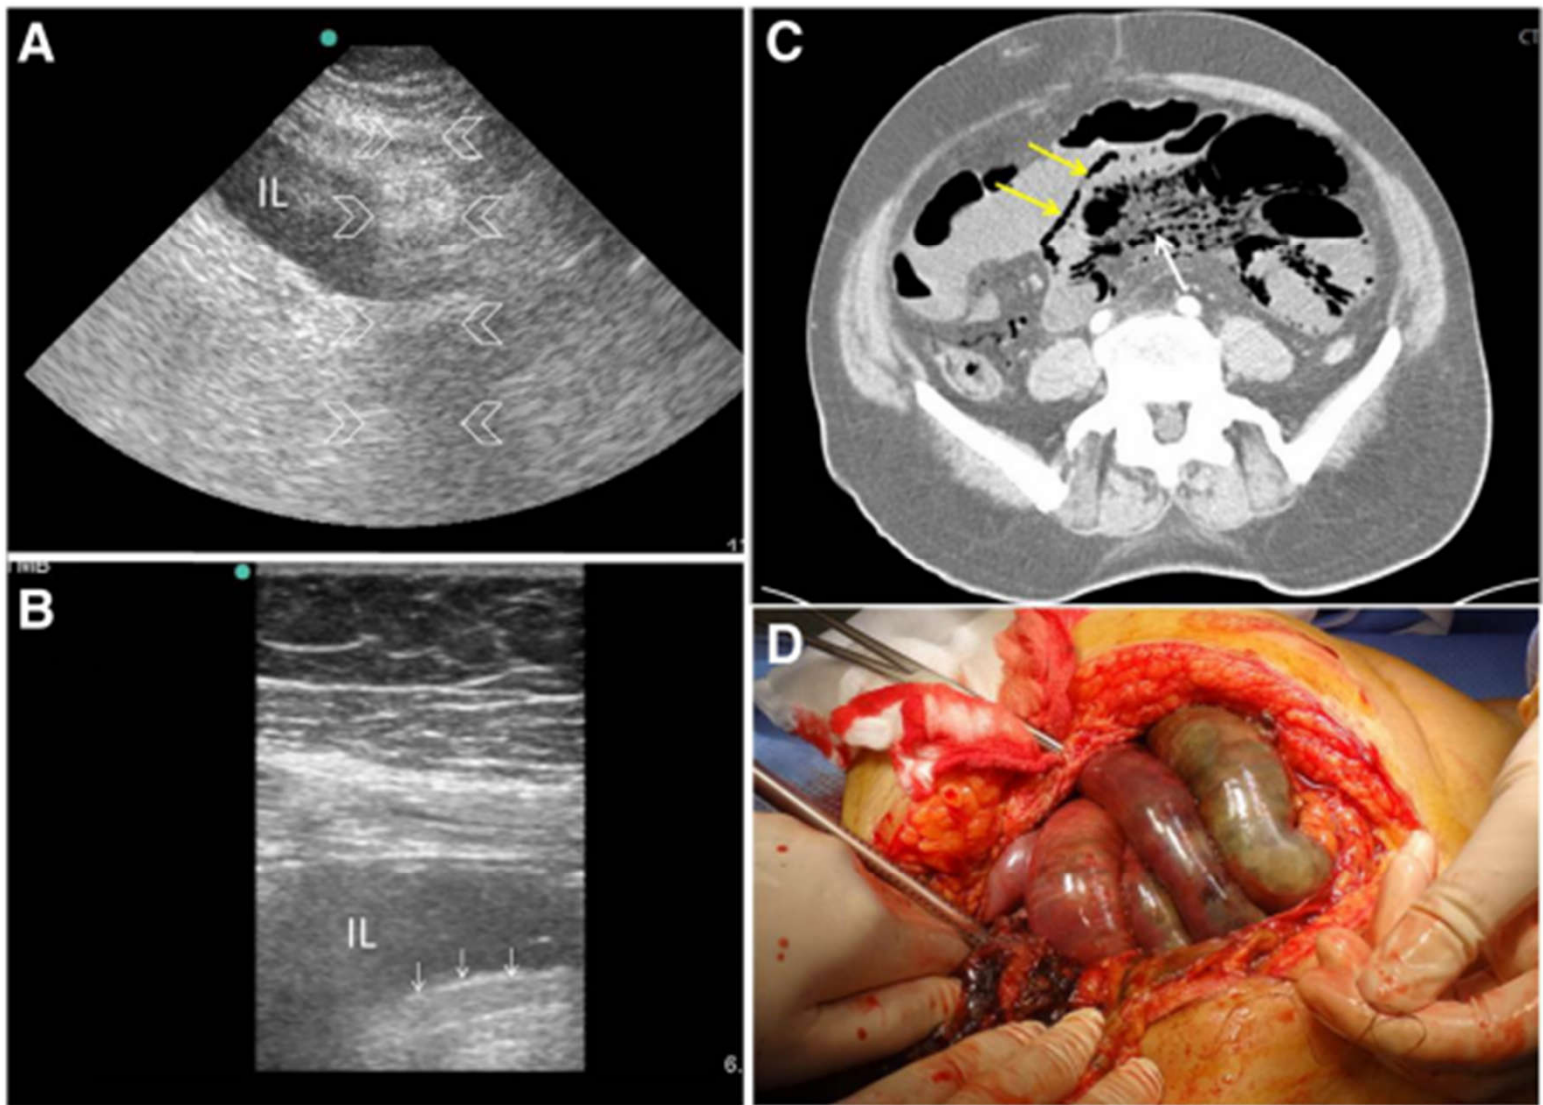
A 60-year old man who had atrial fibrillation developed abdominal pain of 24 h duration. He had a distended tender abdomen. Bowel sounds were negative. POCUS (a) was done using small print convex array probe (3–5 MHz). It was unexpectedly difficult because of obesity and unusual abdominal reverberation artefacts (arrowheads). The ileum (IL) was dilated and non-active. The high-frequency linear probe (10–12 MHz) (b) confirmed these findings and detected gas within the bowel wall shown as tiny white dots (white arrows). CT angiography scan (c) showed superior mesenteric artery occlusion with massive bowel ischaemia. The small bowel loops had non-enhancing walls and pneumatosis intestinalis (yellow arrows). There was massive gas in the mesenteric vessels (white arrow). Laparotomy confirmed these findings (d). Clinical image, Courtesy of Dr Hussam Mousa, Department of Surgery, College of Medicine and Health Sciences, UAE University, Al-Ain, United Arab Emirates
